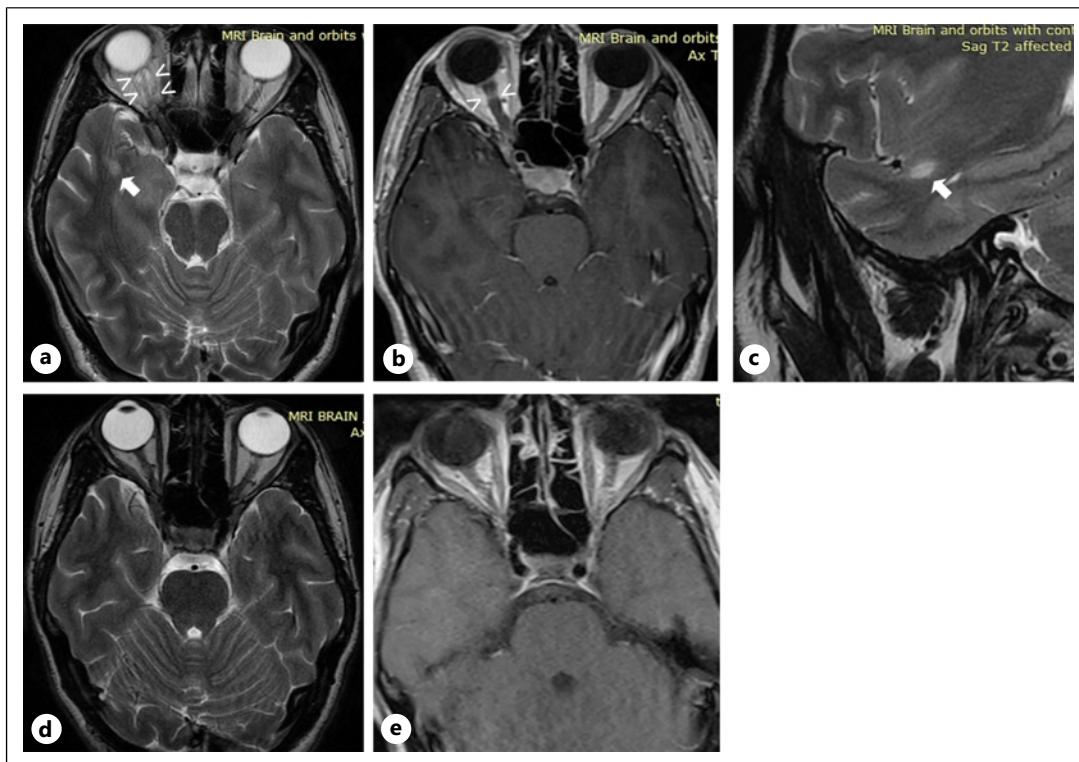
Representative axial (a) T2-weighted image from an initial MRI study of the brain and orbits showing T2-hyperintense lesions in the intracanalicular portion of the right optic nerve (open arrowheads in a), with contrast enhancement of the right optic nerve after gadolinium administration (arrowheads in b). Both the axial and sagittal (c) images showed also a T2-hyperintense lesion in the right anterior temporal lobe (arrows in a and c). d, e In the repeat MRI study following treatment, there is resolution of inflammatory changes in the right optic nerve as shown by the reduction of T2 signal abnormality (d) and no further contrast enhancement (e).
